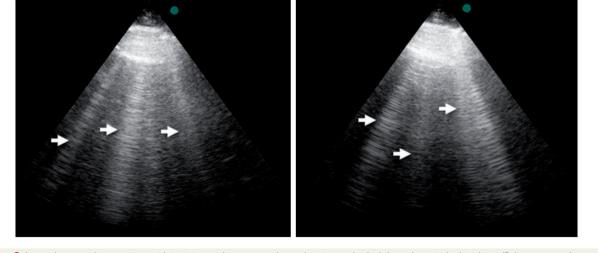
Lung ultrasound in a patient with incipient pulmonary oedema showing multiple, bilateral vertical white lines (B-lines, arrows) consistent with extravascular lung water. Left panel: left lung; right panel: right lung.
